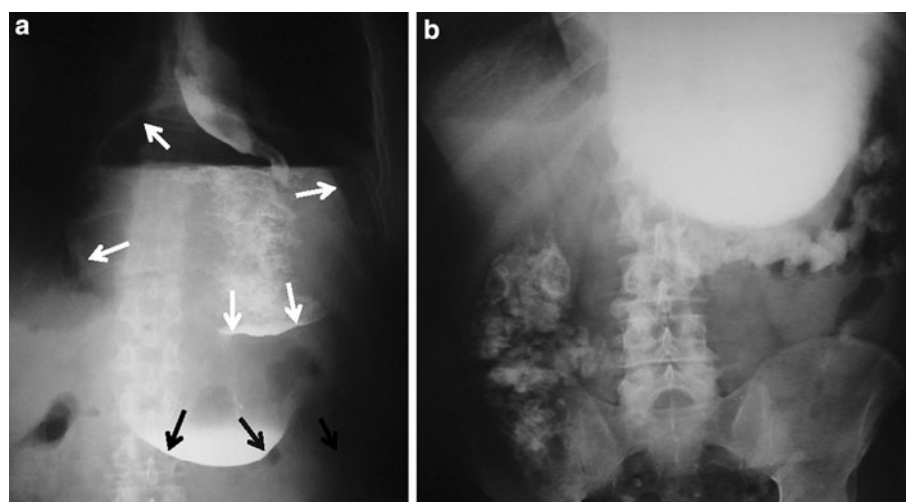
CT showing gastric distension both above and below the diaphragm with little barium passed into the intestines after 24 h (a, b)
